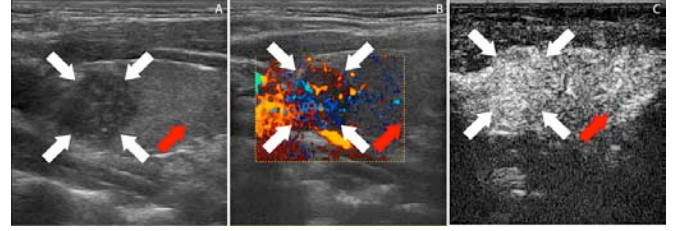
A) HRUS, B) Color Doppler, C) CEUS images of a papillary carcinoma (malignant).
